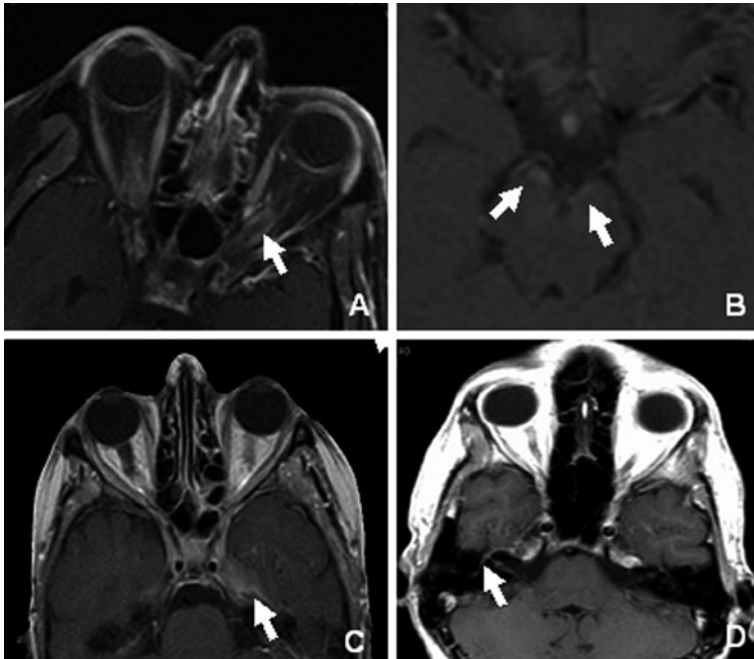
Cranial nerve involvement in four cases of LMD. Contrast-enhanced axial T1-weighted images show enhancement and involvement of cranial nerves: (a) left optic nerve sheath (arrows); (b) oculomotor nerves (arrows); (c) left Meckel's cave (arrows); and (d) right facial nerve (arrows)
